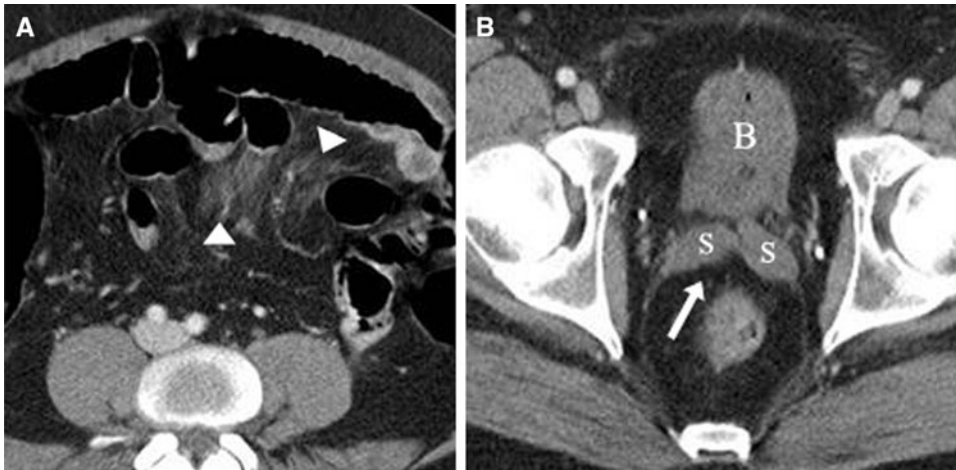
A 50-year-old male status post-blunt abdominal trauma. A Axial contrast-enhanced CT of the abdomen demonstrated fat stranding (arrowheads) in the mesentery. B Axial contrast-enhanced CT of the pelvis demonstrated no free fluid (arrow). Bladder (*B*) and seminal vesicles (*S*) are noted. Surgery was not performed. Chart review confirmed that the patient did not have surgically important mesenteric injury.
